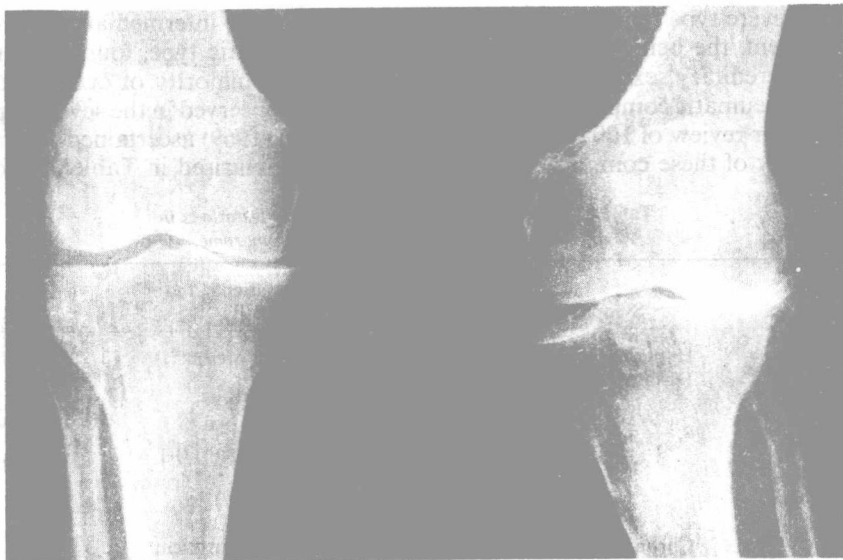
Same patient as Figure 2. X-rays of both knees, showing severe secondary osteoarthritis of the left knee. Arthritis was the presenting symptom. Wrists, fingers and feet were also affected.
